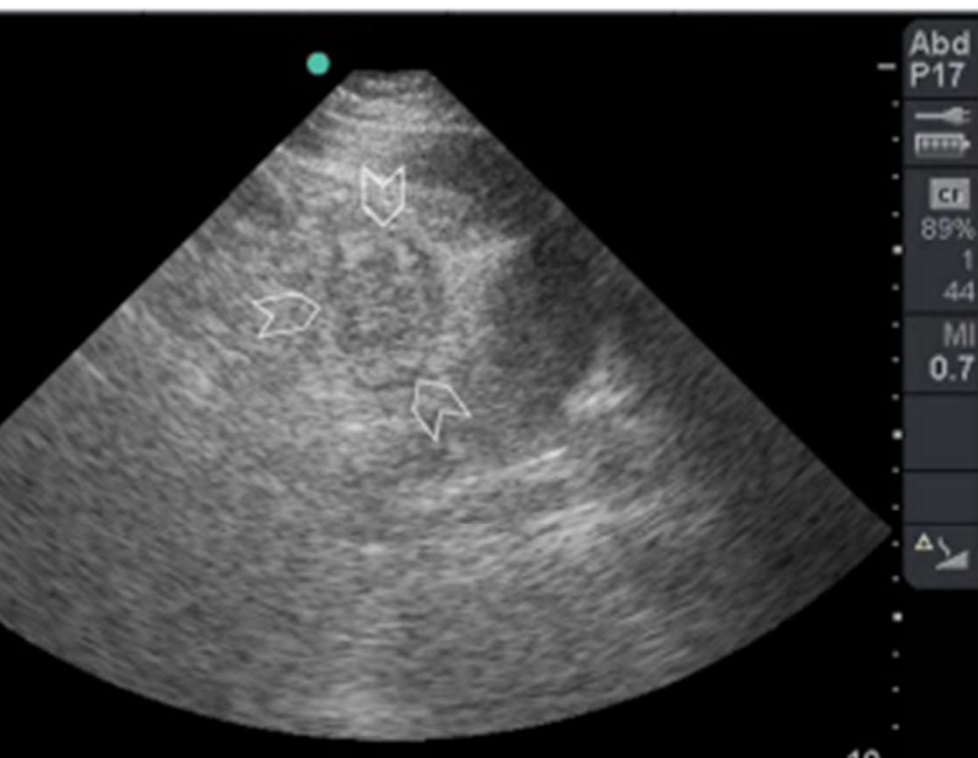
A 32-year-old man presented with left lower quadrant abdominal pain of 5 days duration. Abdominal examination revealed a tender mass in the LLQ. The patient had leukocytosis and elevated CRP. POCUS study (a) using a portable ultrasound machine with a small print convex array probe with a frequency of 3–5 MHz showed a rounded mass (arrowheads). A more detailed POCUS study using a high-frequency linear probe showed that the mass had a rounded folded edge giving it the classical *saw-tooth* appearance. The hypoechoic area represents the muscularis propria (arrow).
